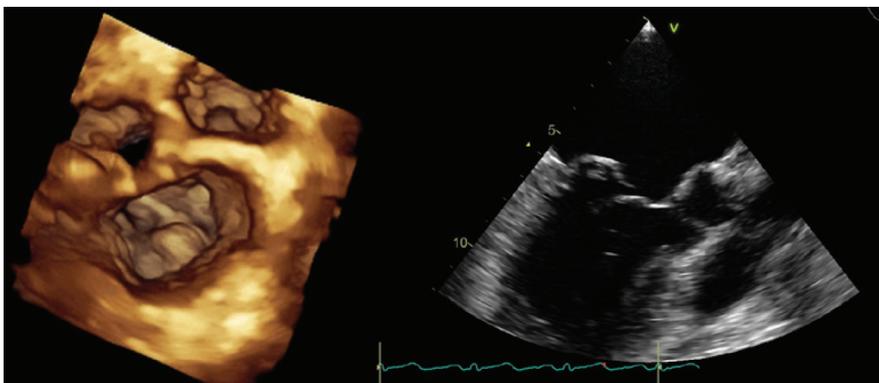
Three-dimensional transthoracic and transesophageal echocardiography showing mitral valve prolapse (P2 scallop).
